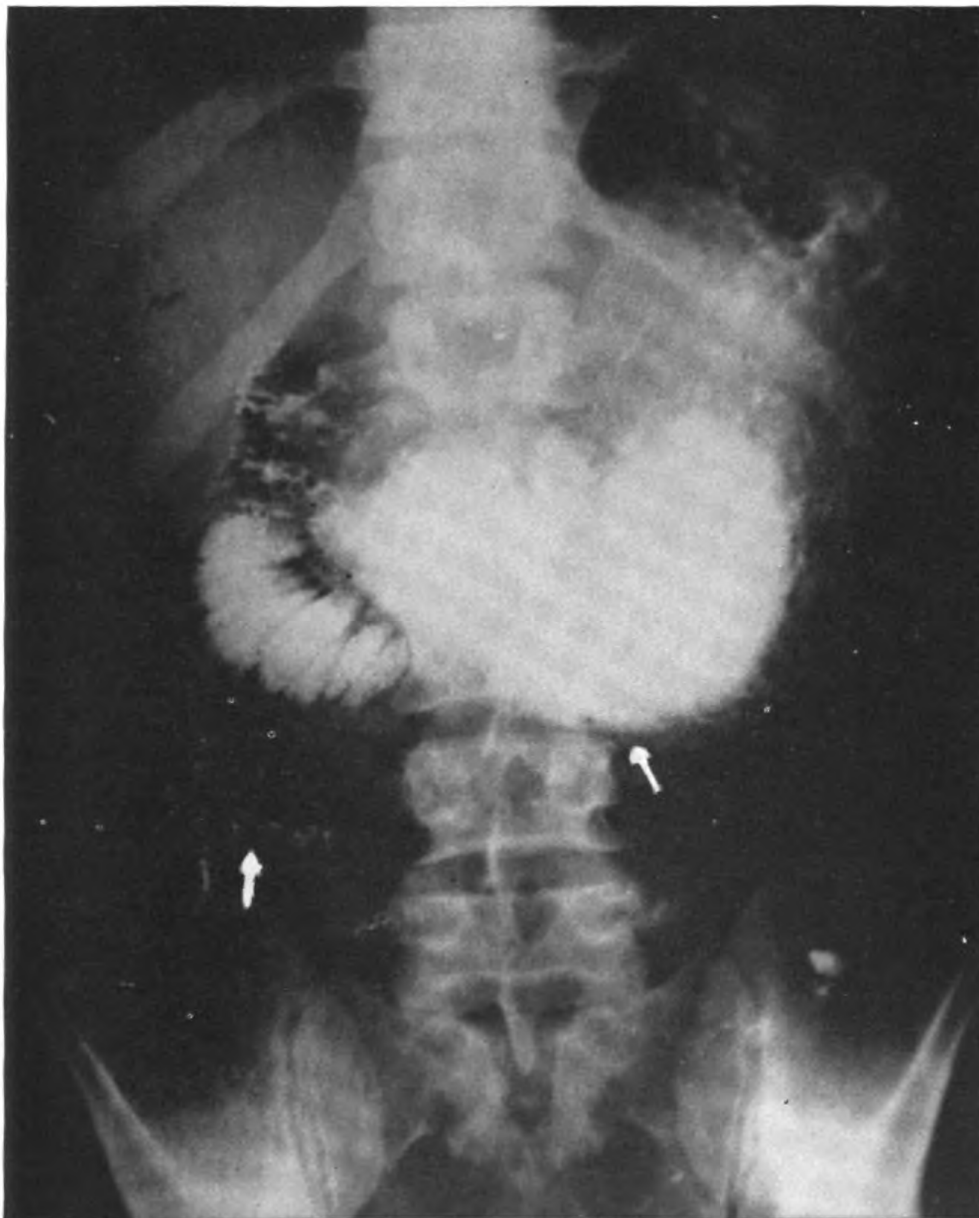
Roentgenogram of barium meal 4 hours after ingestion.
